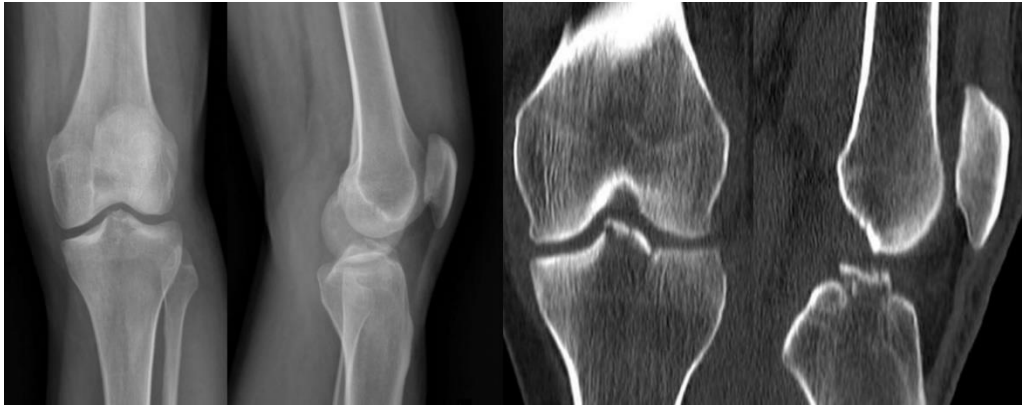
Pre-operative radiography and computed tomography (CT) scan showing a type IV tibial spine fracture (TSF)
